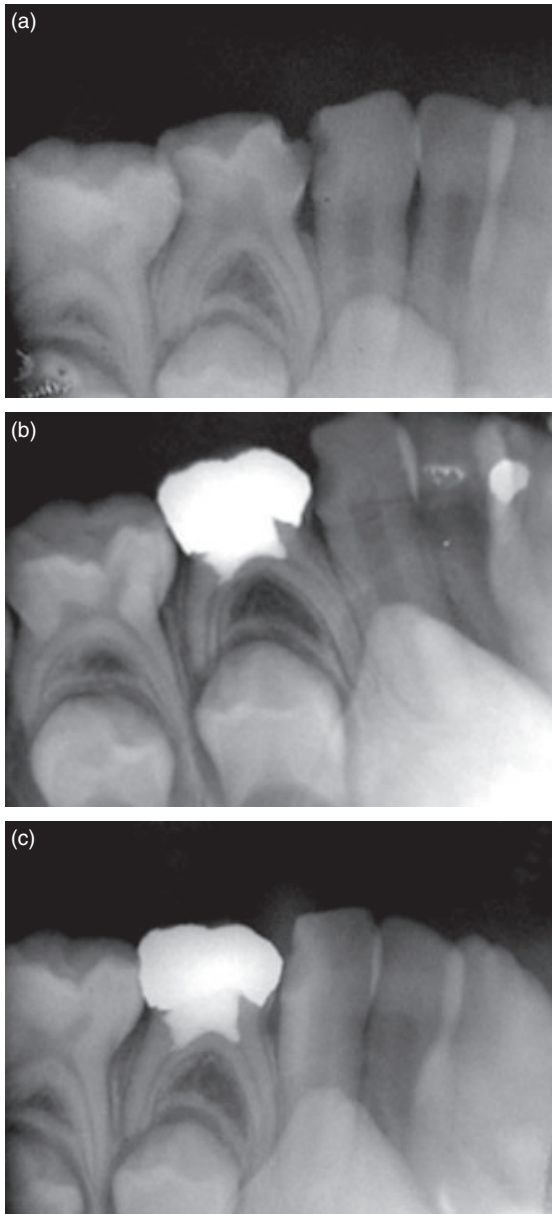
(a) Initial radiographic feature of successful pulpotomy with formocresol. (b) Radiographic feature after successful pulpotomy with formocresol after 3 months. (c) Radiographic feature after successful pulpotomy with formocresol after 6 months.
